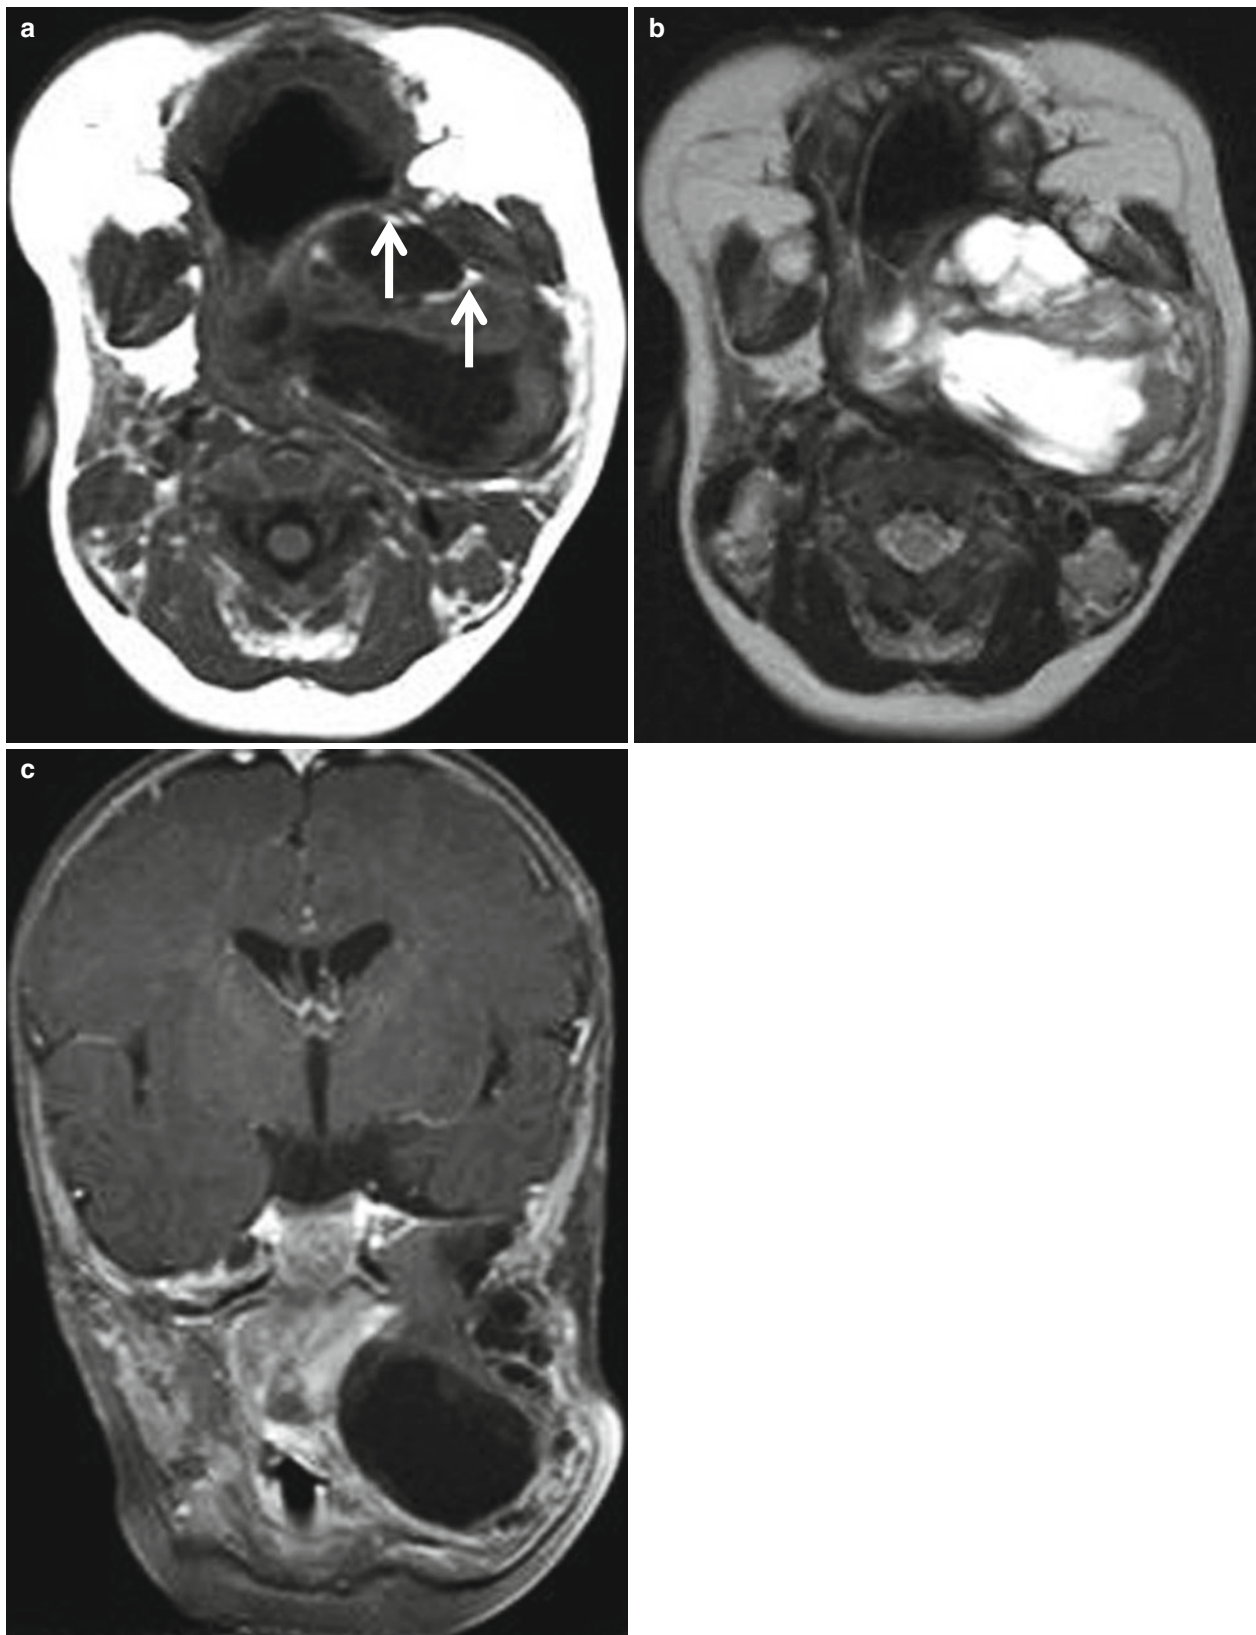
Teratoma in a 3-month-old infant. (a) Axial T1-weighted MR image shows a large lobulating, complex mass in the left infratemporal fossa. The mass contains small foci of fatty tissues with high signal intensities (*arrows*). (b) Axial T2-weighted MR image shows peripheral solid and central cystic portions. (c) Contrast-enhanced
